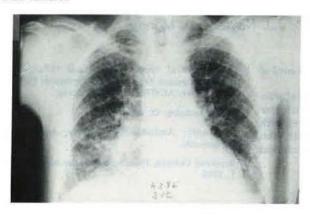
Chest X-ray showing diffuse interstitial infiltrates at second admission.
